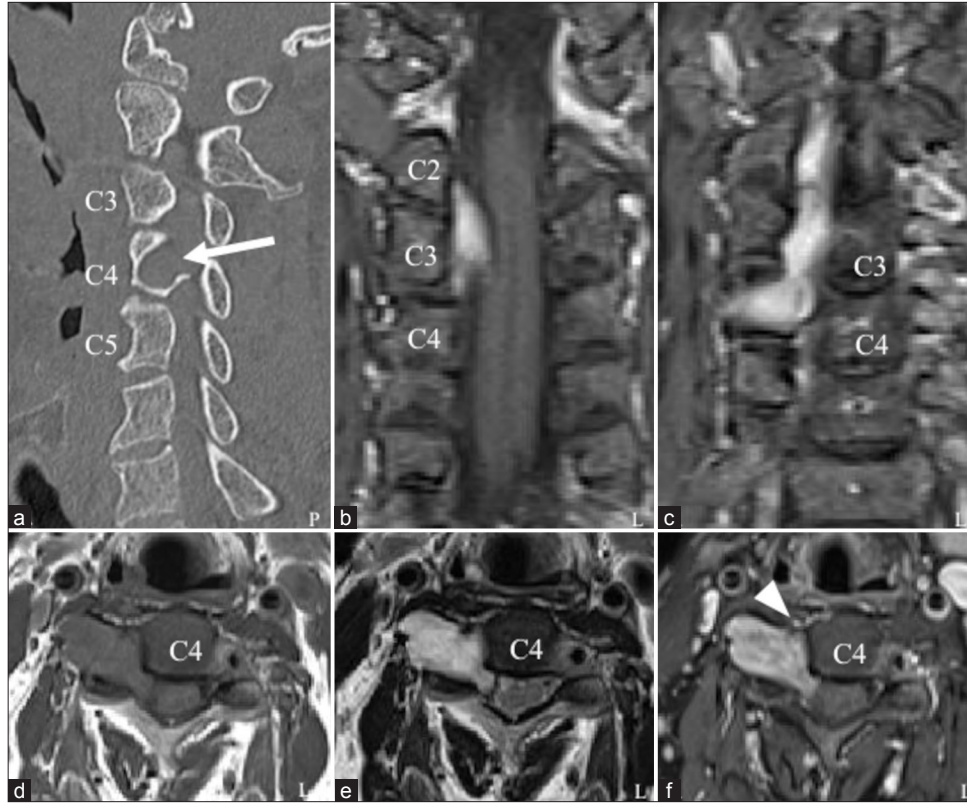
Initial radiological characteristics. Sagittal computed tomography images reveal the enlargement of the right C3/4 intervertebral foramen (arrow) and no calcification (a). A cervical dumbbell-type tumor exhibits isointensity on an axial T1-weighted magnetic resonance image (d) and heterogeneous hyperintensity on an axial T2-weighted magnetic resonance image (e). The tumor is heterogeneously enhanced with a gadolinium contrast agent (f). The tumor is located at the C2–4 level (b and c: coronal T1-weighted images with a gadolinium contrast agent). The cervical spinal cord and right vertebral artery (f, arrowhead) are compressed by the tumor.
